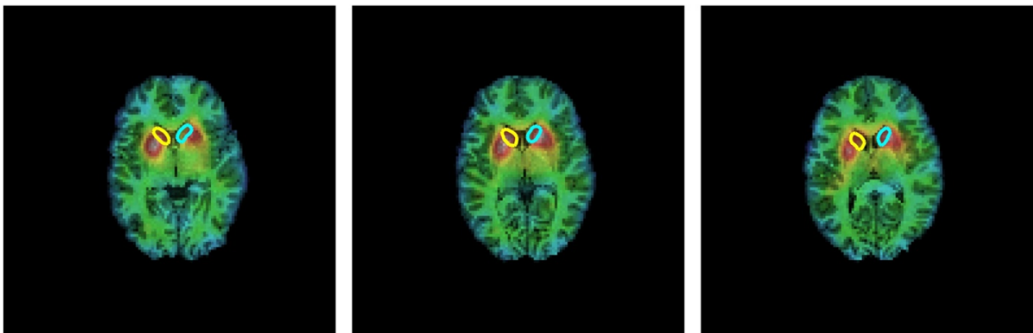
The caudate (region of interest) visualised on a T1 weighted MRI and [ $^{123}\text{I}$ ]-IBZM background
